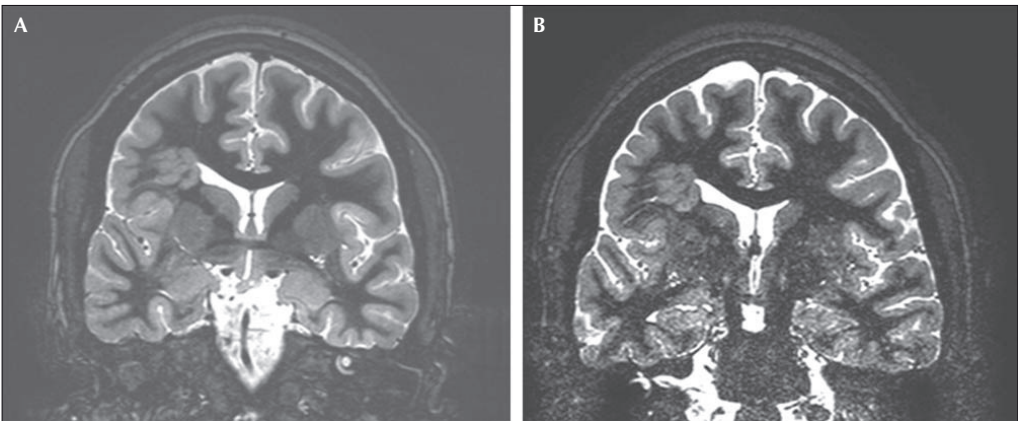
28-year-old woman with partial epilepsy (pat # 4 in table 1) and a right parietal, subcortical (transmantle) heterotopia on MRI. A) 3T, T1-w IR modulus image shows the right-sided malformation (white circle). B) 3T, surface coil T1-w IR modulus image provides slightly better demarcation of subtle details in the right-sided, heterotopic grey matter. Decreasing signal-to-noise ratio at a distance from the surface coil with markedly deteriorated image quality in the inferior portion of the image.
